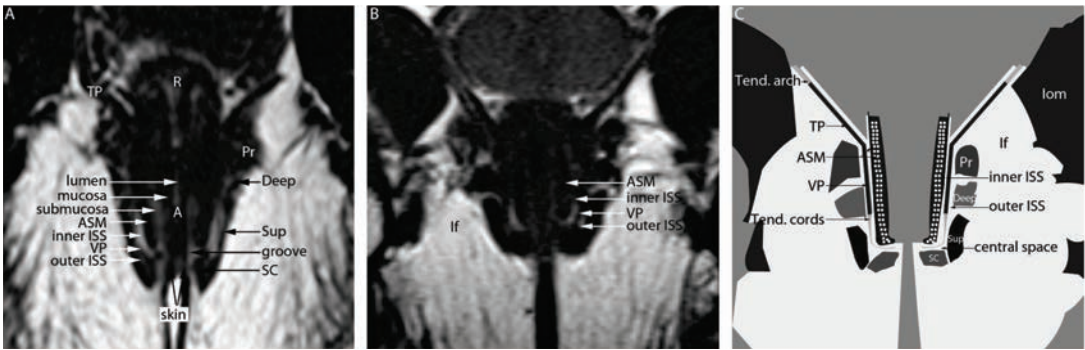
T2-weighted turbo spin-echo endoanal coil MRI studies by Rociu et al.
